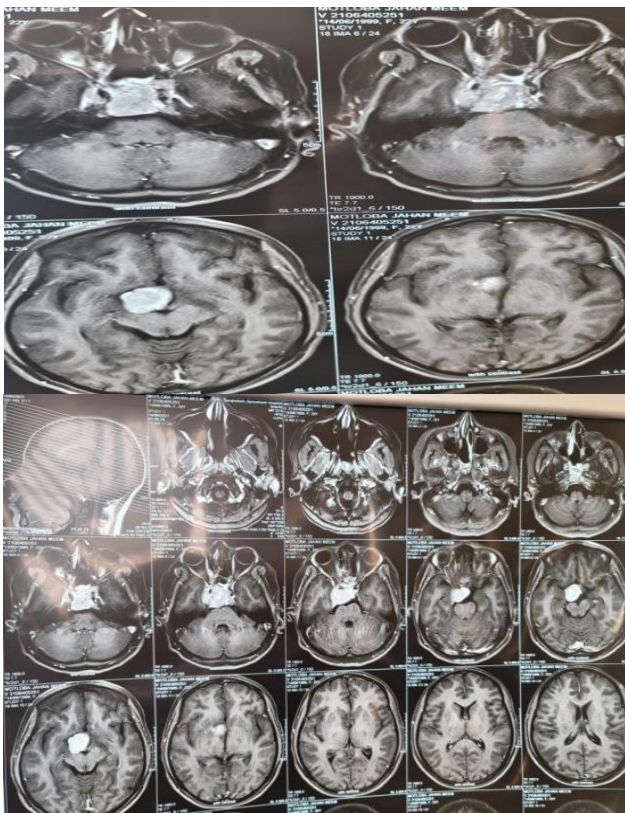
MRI brain showed large lobulated mass measuring 4.1×3×3.2 cm with intense enhancement at clivus with right parasellar extension, the right cavernous sinus was encased.
